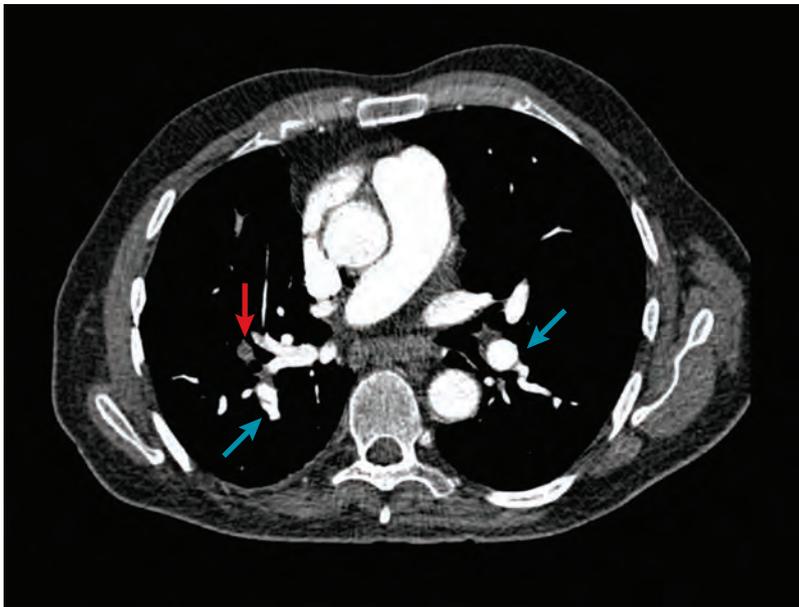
CTPA of a patient with acute and chronic signs of PE. Red arrow denotes acute pulmonary embolism (PE). The blue arrows point at webs in the pulmonary artery tree suggestive of chronic thrombus remains. CTPA, CT pulmonary angiography.
